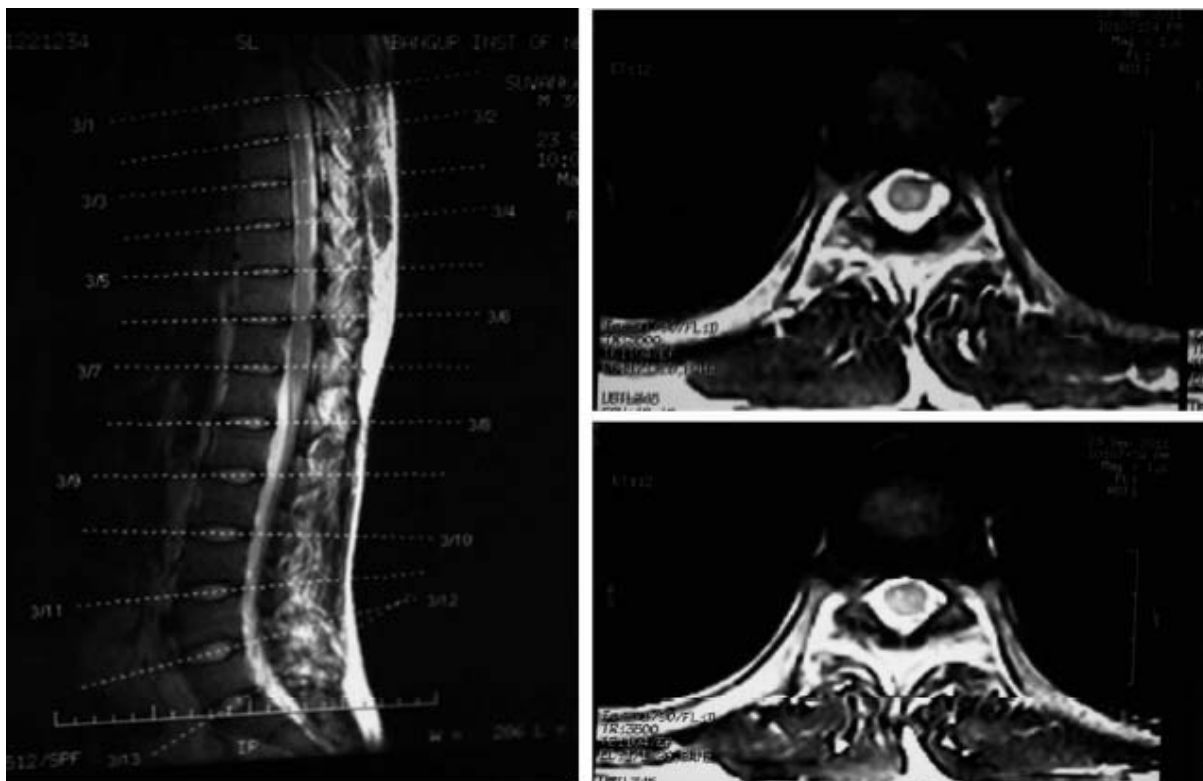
T2 weighted MRI of dorsal spine showing hyperintensity at the level of T6–T7 spine.
